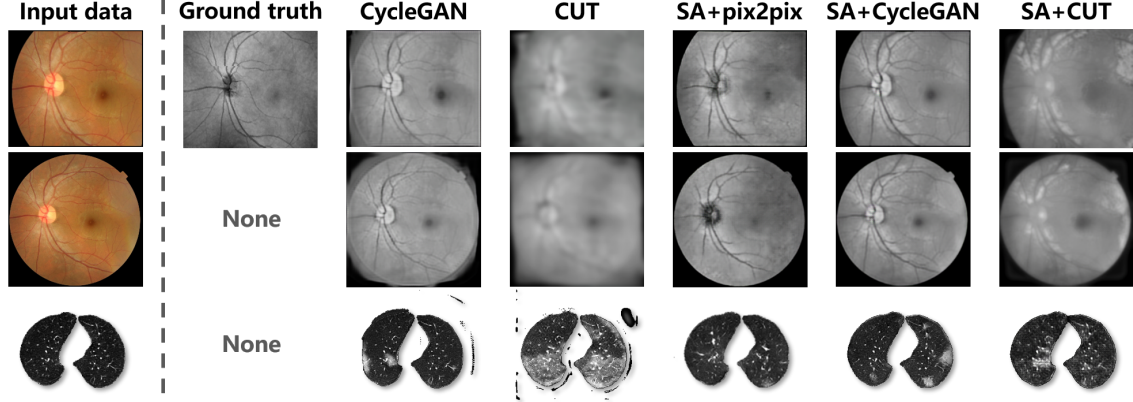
Visual comparison of the synthesis results. The first two row present the cross-modality translation of fundus images using the aligned and original data, and the third row is the synthesis of COVID-19 infected CT scan.
